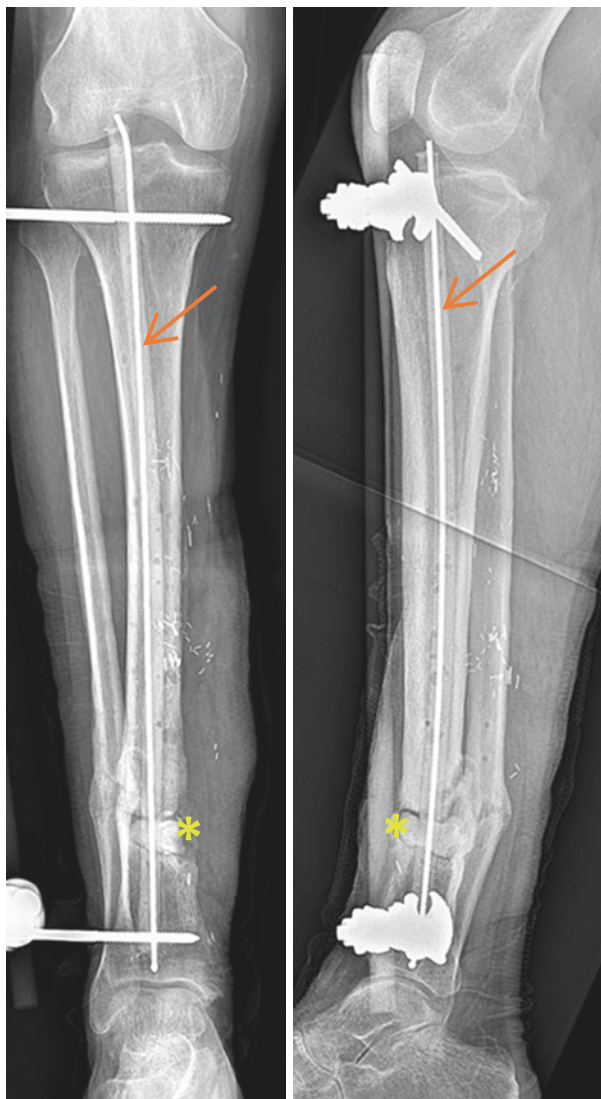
AP and lateral radiographs of the right tibia after the first stage of our revision reveal a bone graft spacer filling the osseous defect, an antibiotic intramedullary rod, and an external fixator in place. Arrow: Antibiotic-impregnated cement surrounding intramedullary guidewire. Asterisk: Antibiotic-impregnated cement spacer filling bone void
